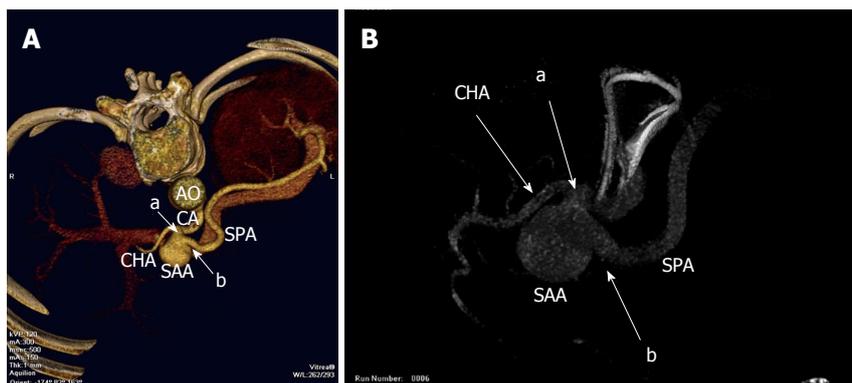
Three-dimensional computed tomography reconstruction. A: A 3-cm splenic artery aneurysm in the proximal splenic artery with afferent (a) and efferent (b) artery; B: Angiography demonstrating a 3 cm splenic artery aneurysm at the same location with afferent (a) and efferent (b) artery. AO: Abdominal aorta; CA: Celiac artery; CHA: Common hepatic artery; SAA: Splenic artery aneurysm; SPA: Splenic artery.
